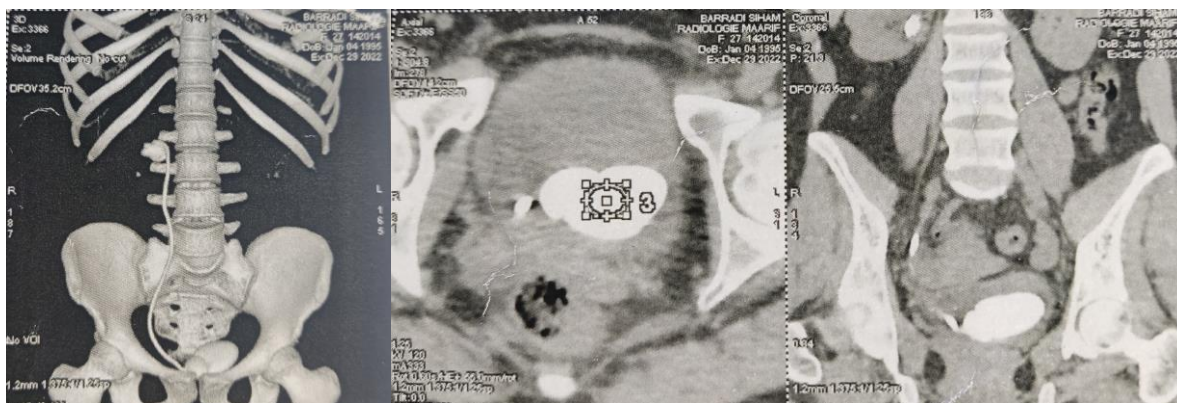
CT imaging revealing extensive calcification of the proximal ureteral stent and significant calcification in the distal segment, along with the presence of a large bladder stone
